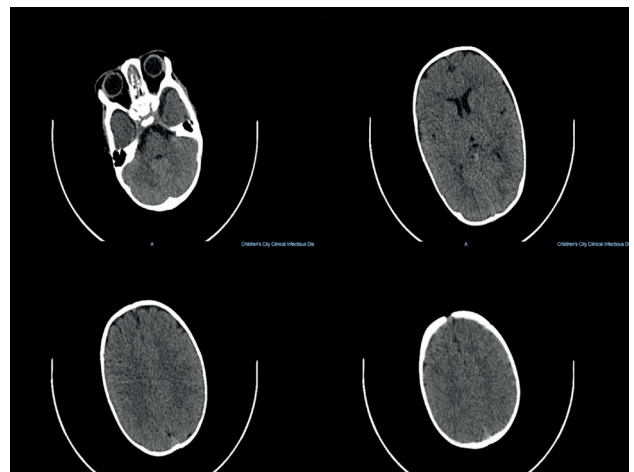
Cranial CT scan: benign enlargement of frontoparietal subarachnoid space.
